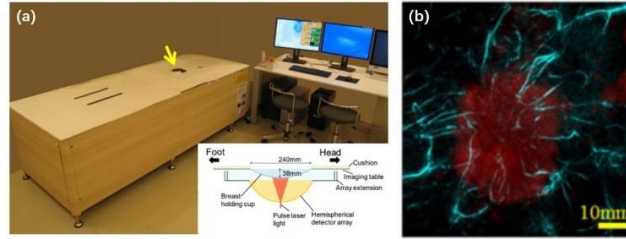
(a) Photograph of PAM-03. (b) Overlaid PAI (cyan)/MRI (red) results of a breast tumor lesion.<sup>[36]</sup>
